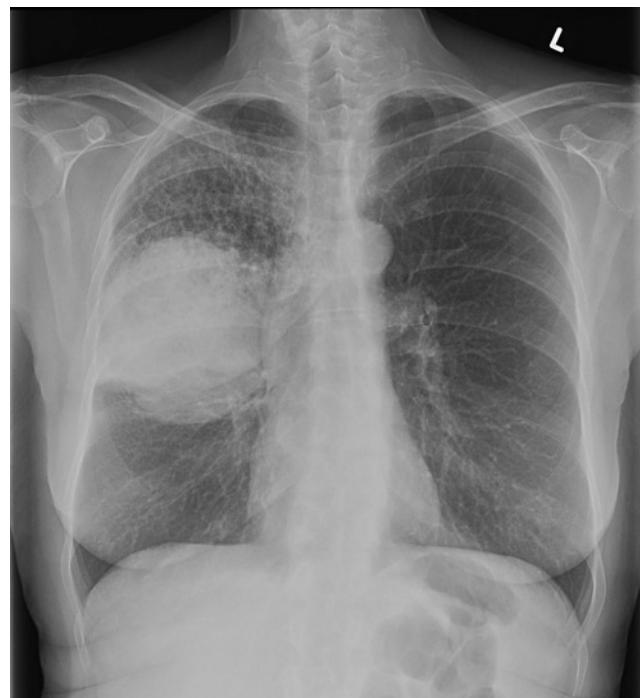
Chest X-ray of a patient with a carcinoma of the right upper lobe scheduled for possible lobectomy or pneumonectomy. The purpose of the preoperative anesthetic assessment of this patient is to stratify the patient’s risk and to identify factors which can be managed to improve the perioperative outcome.
